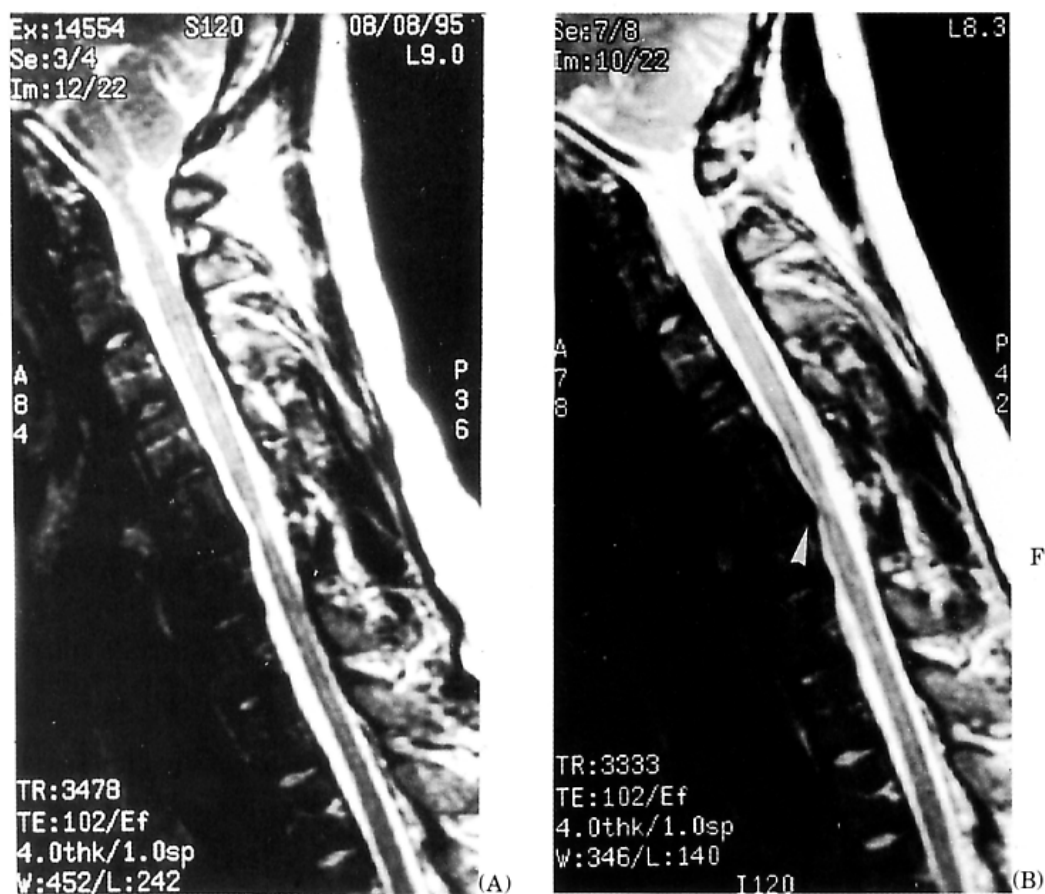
(A), T2-weighted MR image, in the neutral position. The cervical cord is atrophic at the C5-C6 level, but not compressed. (B), T2-weighted MR image, in the flexion position. The cervical cord is compressed anteriorly at C5-C6 level (arrowhead).
